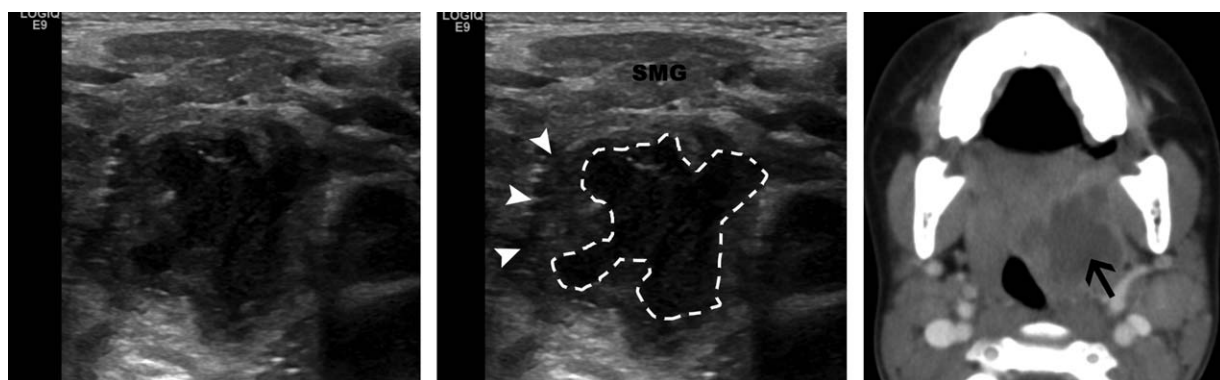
Ultrasound and computed tomography (CT) images from the same patient. The far left and center images are identical, the center image being marked to identify the structures. The irregularly marginated hypoechoic region (outlined by white dashed line) is consistent with a left peritonsillar abscess. Again the tonsil (white arrow heads) and submandibular gland (SMG) are labeled for reference. The CT image (far right) shows the corresponding abscess (black arrow).
